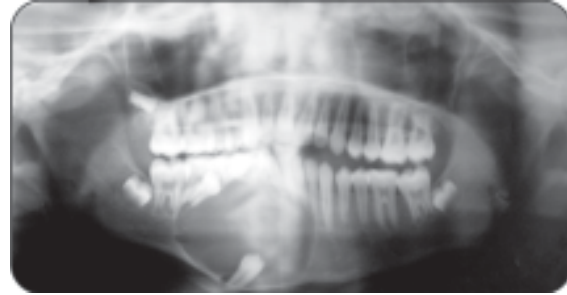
Radiograph of calcifying epithelial odontogenic cyst
